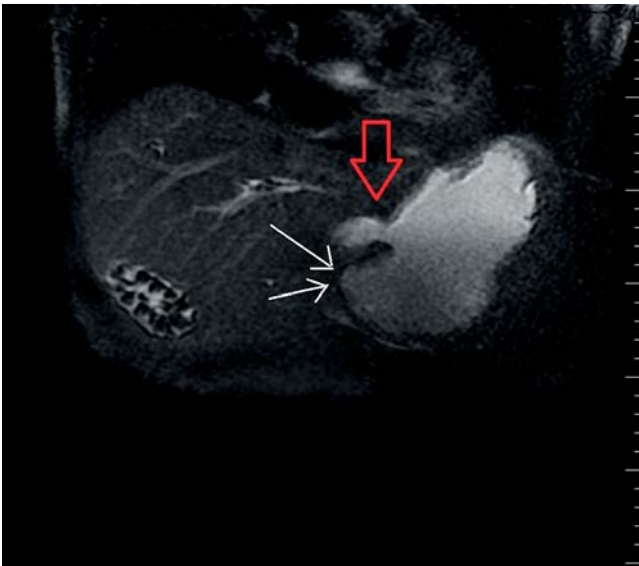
Coronal T1-weighted magnetic resonance imaging (MRI) scan showing the atypically placed pylorus and bulb (red arrow), with the expected position of the pylorus indicated by the white arrows.
